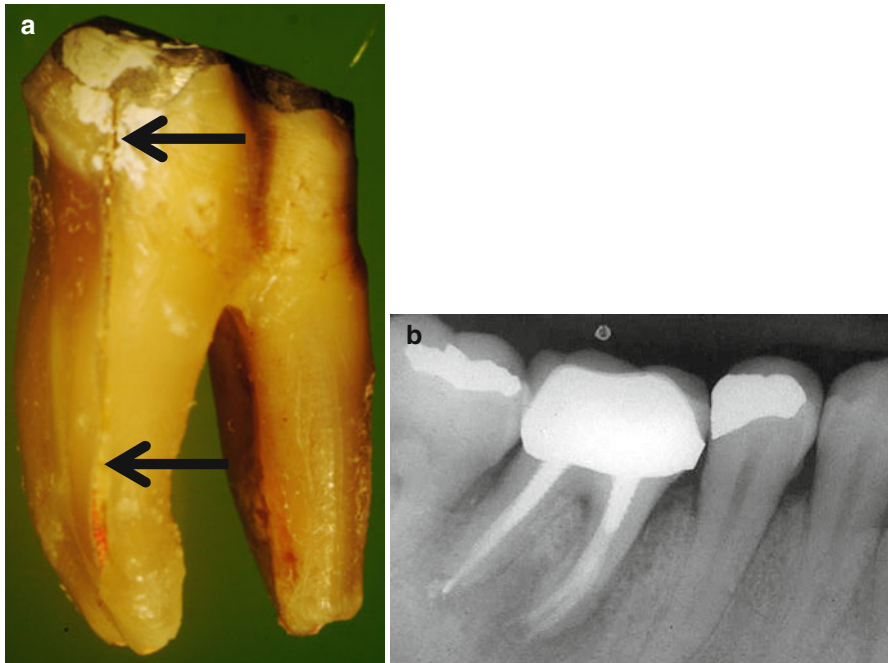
(a, b) The patient presented to the dental office with a history of acute exacerbation in the right side of the mandible. Three years earlier, the root canal treatment was retreated and a new PFM crown placed. On clinical examination, there was redness at the attached mucosa adjacent to the mandibular first molar, sensitivity to percussion, and 8 mm probing defect at the MB site. The periapical radiograph (b) revealed well-obtained root canals and two dowels in the mesial and distal roots. Large “halo”-type radiolucency combined with a lateral one on the mesial aspect of the mesial root can be seen in the radiograph. Although the radiographic appearance and the probing hinted that there may be a VRF in this case, the diagnosis that was done was symptomatic apical periodontitis. The tooth was extracted because the prognosis for a new retreatment was poor. The extracted tooth (a) shows a VRF in the mesial root (arrows) that extends from the coronal area to the apical third of the root and a vertical root fracture in the bifurcation aspect (mesial) in the distal root as well. Most likely, this is a case of crown-originated fracture that progressed to the two roots as well
